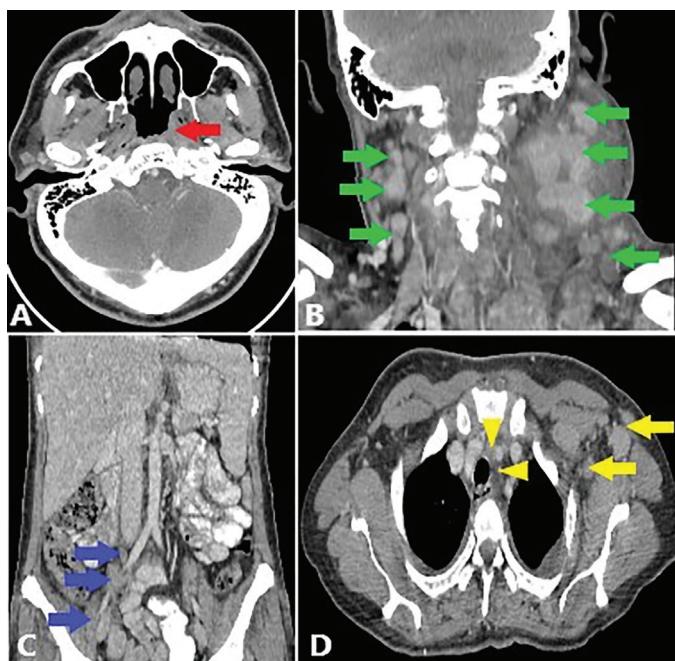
Contrast-enhanced CT scan of neck, thorax, abdomen and pelvis. Axial image at the level of the nasopharynx shows mild thickening of the left torus tubarius compared with the right side, with effacement of the left FOR (red arrow), without any enhancing lesion seen (A). Coronal image of the neck shows bilateral cervical nodes at levels II, III, IV and V (green arrow) (B). Coronal image of the abdomen and pelvis shows multiple enlarged LNs surrounding the right common and external iliac vessels (blue arrow; C). An axial image of the thorax shows multiple enlarged left axillary and paratracheal LNs (yellow arrow and yellow arrowhead, respectively) (D).
